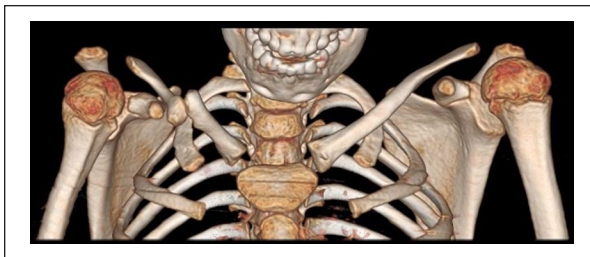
A 3 dimensional computed tomography reconstruction showing the right mid-clavicular bone gap with well corticated ends and no bridging. The medial clavicular half points upwards in regards to the lateral larger half.
